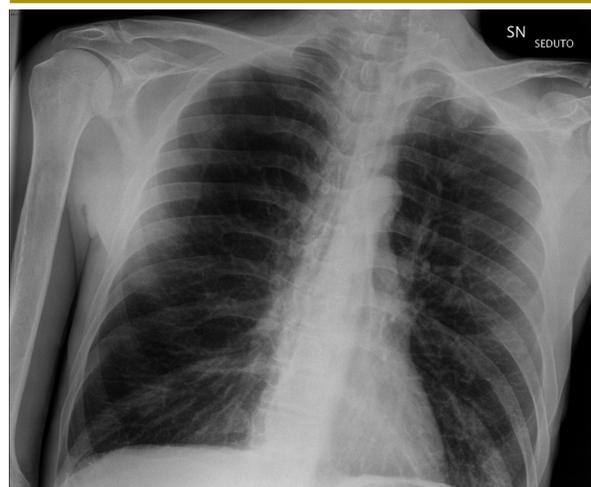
The patients' Chest x-Ray showing lung inflation.
